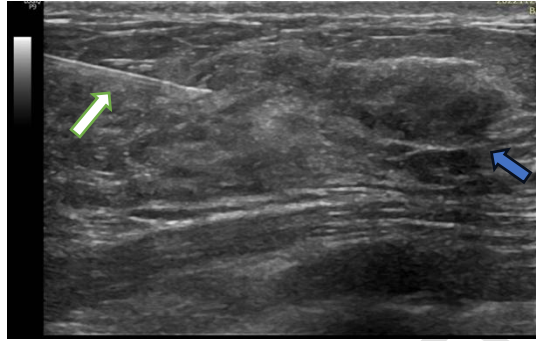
Grayscale ultrasound in the 02:00 Radio in the left breast the shape was irregular, and margins were non-circumscribed, parallel orientation, posterior shadowing was present (Blue arrow).
